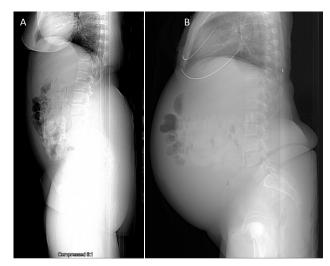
A. Scout lateral abdominopelvic radiograph from CT obtained in 2013. B. Scout lateral radiograph from CT obtained in 2017 demonstrates inreased abdominal girth and increased hazy opacity within the abdomen suggestive of interval development of ascites.
